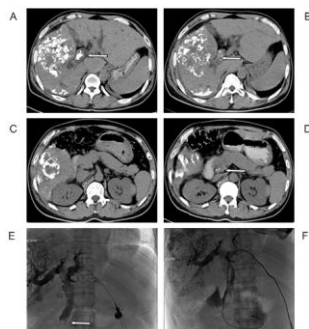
(case 1). (A, B) Abdominal plain CT before TACE showing cancer thrombus containing lipiodol duct (white arrow) in the upper common bile duct.. (C) No mass was observed in the lower end of the common bile duct before TACE. (D) Approx. 3 weeks after TACE, the bile duct cancer thrombus dropped to the lower end of the common bile duct (white arrow). (E, F) The cholangiography image showed a filling defect at the lower end of the common bile duct (white arrow) and placement of internal and external drainage tube.
